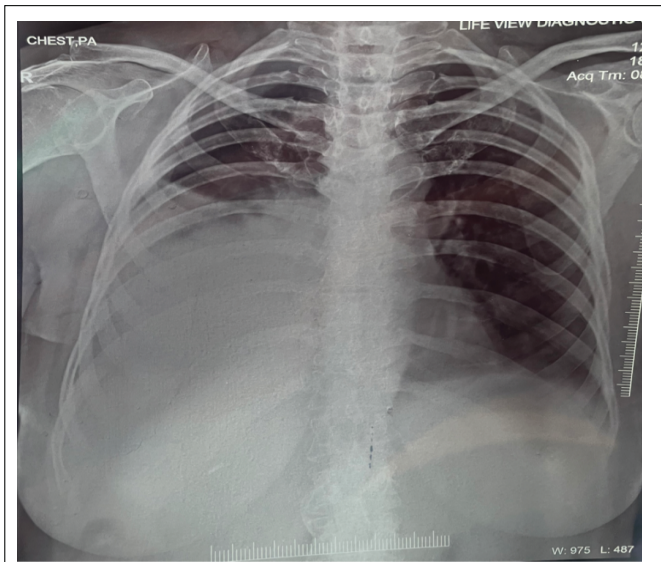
Chest X-ray showing large pleural effusion on right side.
